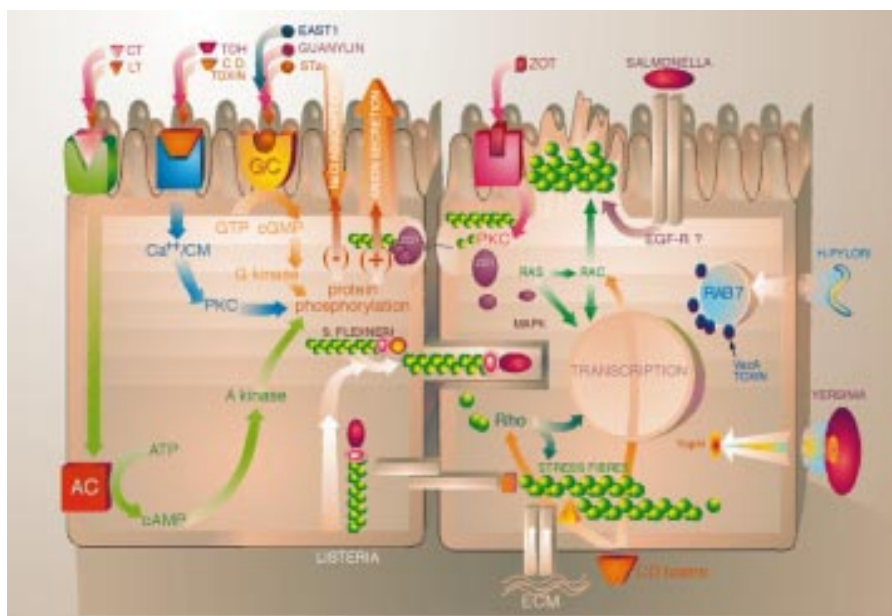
Enterocyte intracellular signalling leading to intestinal secretion. Four main pathways seems to be involved in the intestinal secretion of water and electrolytes: cAMP, cGMP, Ca, and cytoskeleton. These pathways are activated by several enteric pathogens, either directly or through the elaboration of enterotoxic products. CT, cholera toxin; LT, heat labile enterotoxin; TDH, thermostable direct hemolysin; C.D., *Clostridium difficile*; EAST1, enteroaggregative *E coli* heat stable toxin 1; STa, heat stable toxin α ; AC, adenylate cyclase; GC, guanylate cyclase; CM, calmodulin; PKC, protein kinase C; ZOT, Zonula occludens toxin; EGF-R, epidermal growth factor receptor; ECM, extracellular matrix.
